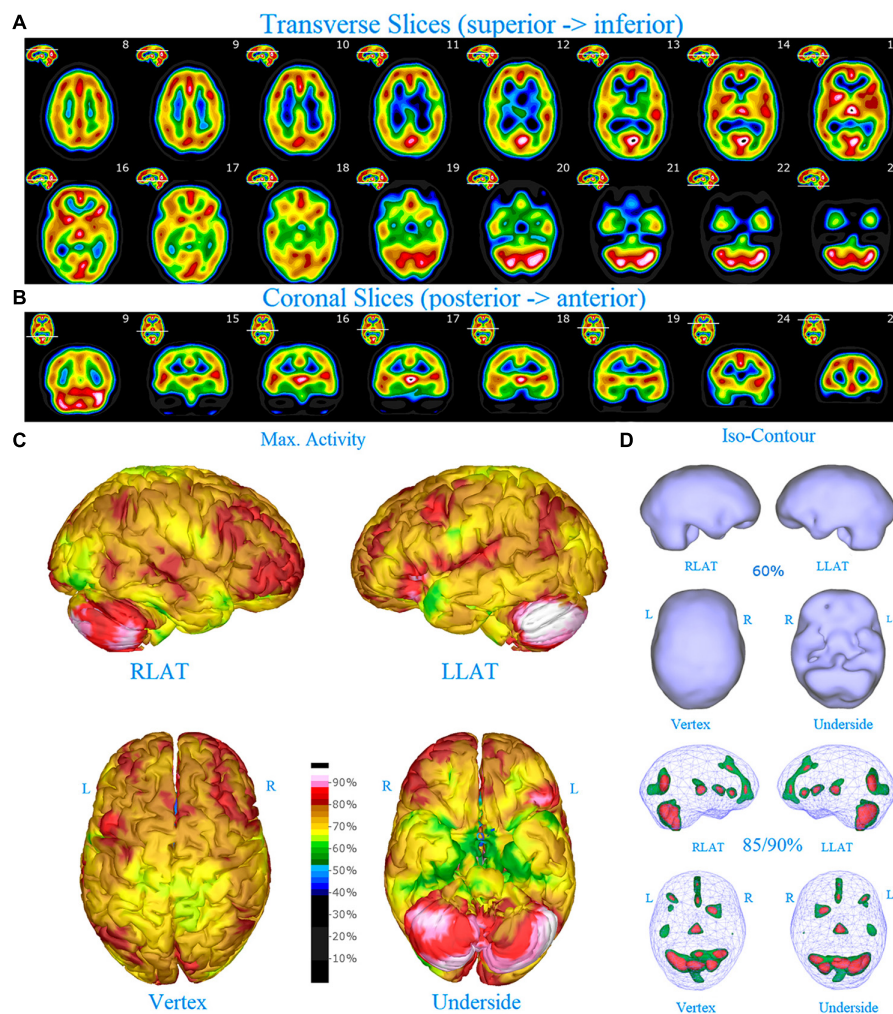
Perfusion SPECT scan of normal control. (A) Horizontal tomograms from a ^{99m}Tc -HMPAO perfusion SPECT scan spanning much of the brain from near superior surface to lower cerebellum (see locator images). (B) Coronal tomograms spanning from anterior margin of cerebellum to anterior cingulate (see locator images). The color scale is scaled relative to the patient's mean cerebral perfusion. Mean blood flow (72%) is in yellow. Color shifts occur at approximately every 0.5 SD (3%) relative to the patient's mean. Details of the brain can be appreciated, including the thalamus, head of the caudate nuclei, lentiform nuclei, anterior cingulate gyri, and distinct cortical regions. The perfusion of the thalamus (white with black central dot), right caudate (on the left side of the tomogram), visual cortex and cerebellum are highest in this example. (C) The modern SPECT scan displayed in 3-dimensional reconstruction. Right lateral (RLAT), left lateral (LLAT), Vertex, and underside views are provided. The color scale is the same as panel (B). (D) Isocontour representations of the SPECT data in 3 dimensions. Surface isocontour representations allow visualization of areas of decreased cortical perfusion. Areas in which perfusion falls below 60% of the maximal cerebral blood flow appear as depressions or holes depending on how far below 60% the perfusion falls. Wireframe representations allow visualization of areas of increased perfusion. Areas with perfusion at 85% of the maximal cerebral blood flow appear in green, while areas at 90% of maximal cerebral blood flow appear in red. It is evident that the thalamus, right caudate, cerebellum, and visual cortex are perfused at 90% of maximal cerebral blood flow. This corresponds to what is seen in the tomograms.
